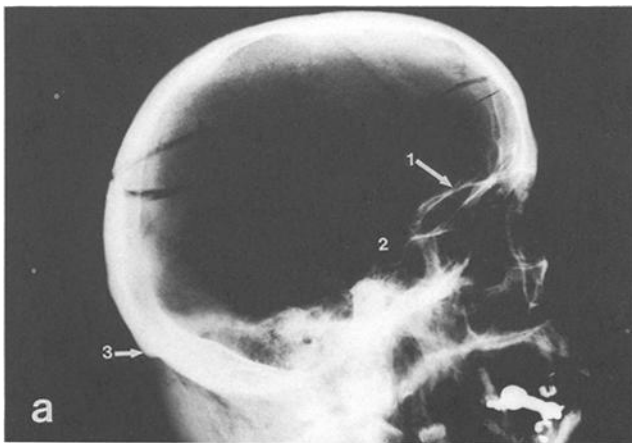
Postmortem lateral radiograph of the skull. Providing comparable orientations were available, features of potential correspondence with Fig. 2b would be: (1) floor of anterior cranial fossa; (2) sella turcica and associated anterior and posterior clinoid processes; (3) external occipital protuberance; (4) general morphology of the skull.
